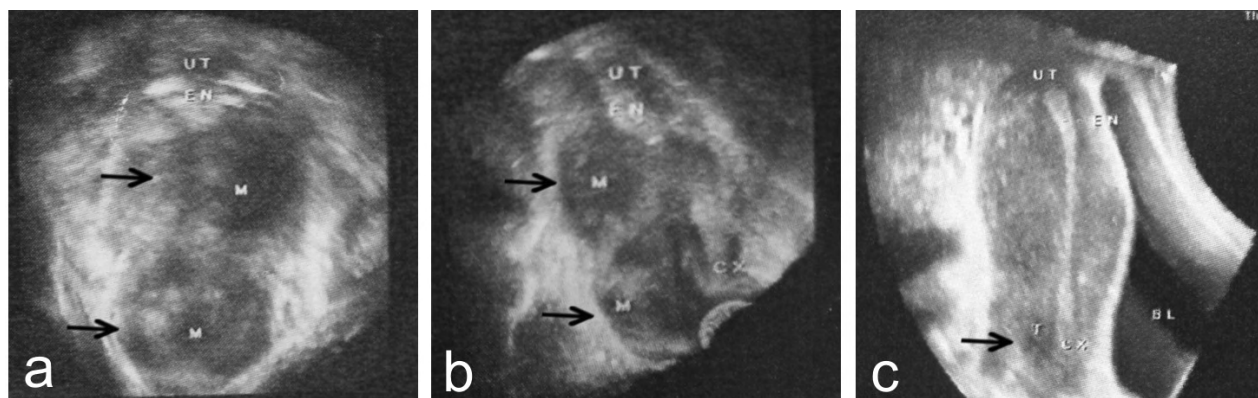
Transvaginal three-dimensional ultrasonography: a, b $4.6 \times 3.0 \times 3.8$ cm and $3.8 \times 2.9 \times 3.3$ cm low echoes (arrows) can be detected on the posterior wall of middle and lower segment of uterus and posterior wall of cervix; disturbance blood flow signal was detected in the mass; resistance index (RI): 0.47-0.51. c the mass (2.2×1.6 cm, arrow) reduced significantly after chemotherapy.
